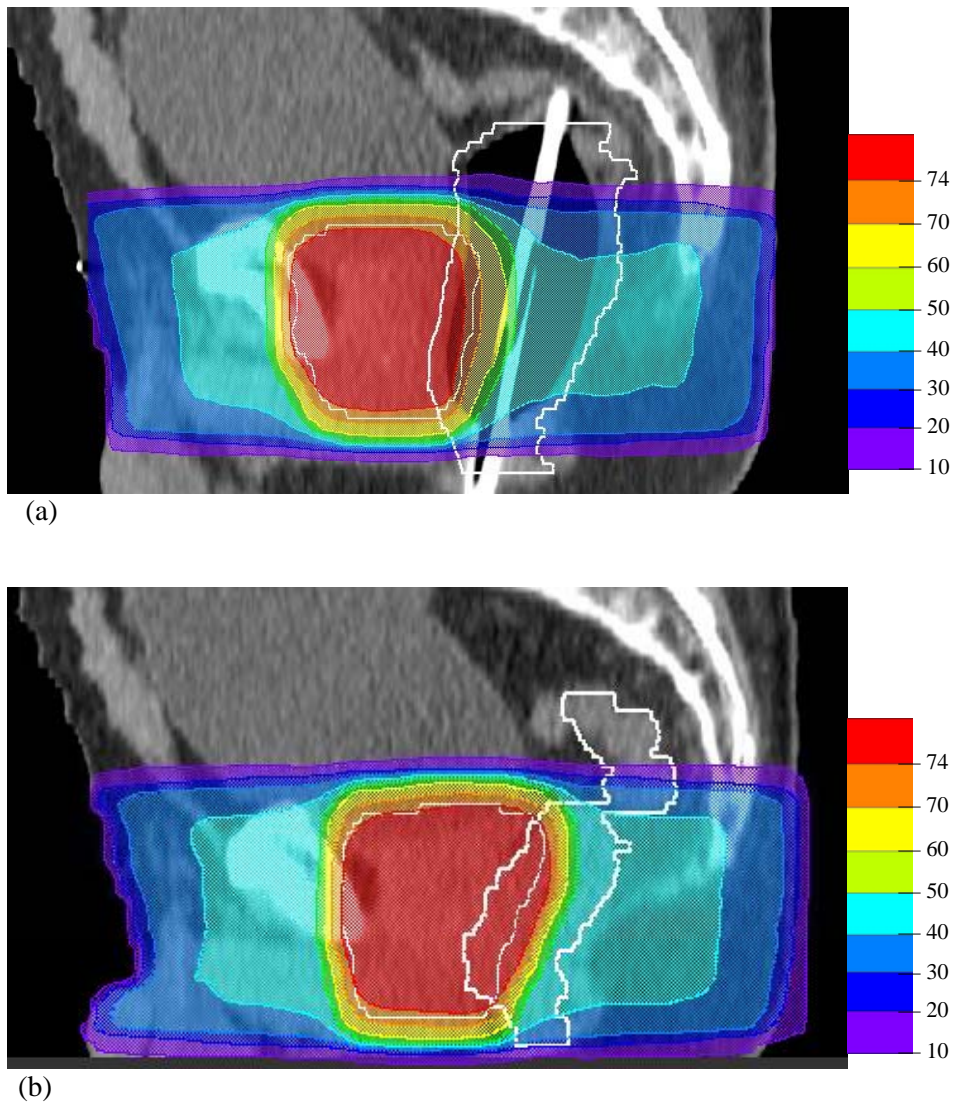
Sagittal CT images with dose distribution, in Gy, for 3D-CRT PTV-P, for (a) No-ERB and (b) ERB2. PTV (prostate + 10 mm margin) and rectal outer contour are highlighted (white lines).
